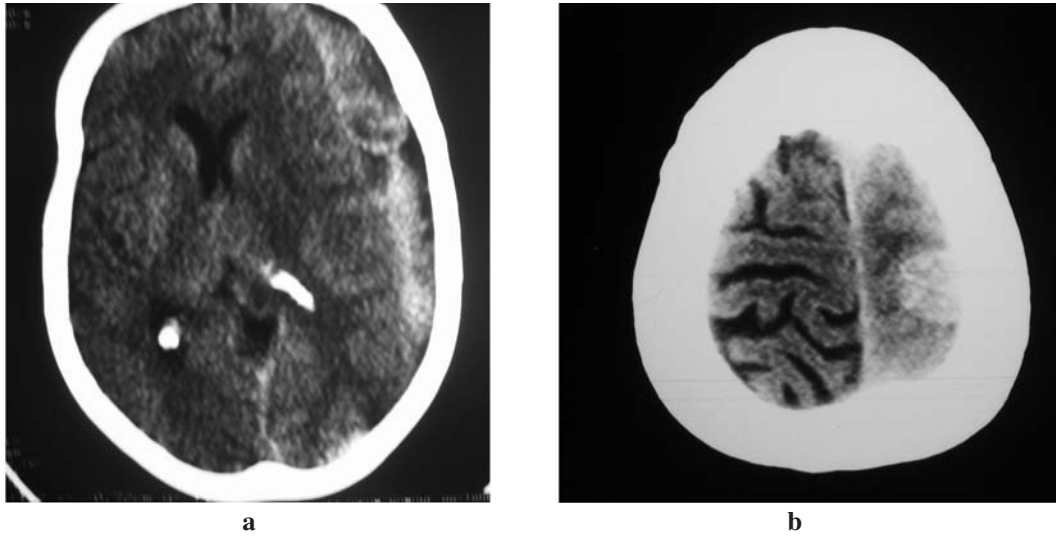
Axial non-contrast-enhanced computed tomography shows left subdural hematoma with acute and subacute components (a). Contrast-enhanced CT section through the vertex reveals a homogeneously enhanced hyperdense lesion in consistency with meningioma (b).
